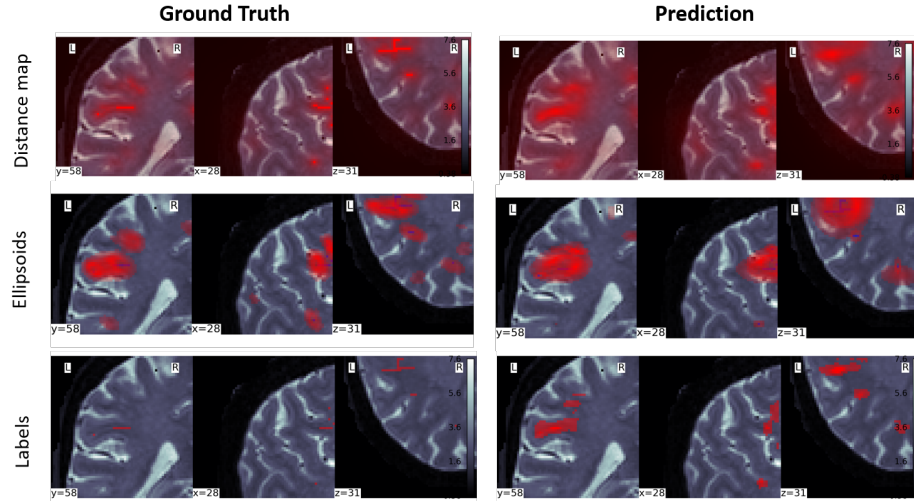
Comparative visualization of gold standard and predictive model outputs on an example patch. The first column exhibits the 'gold standard', expert-annotated examples for comparison, the second column displays the corresponding outputs generated by our 3D-UNET (distance map) and 3D RCNN models. All images are overlaid on T2-weighted MR image patches.
